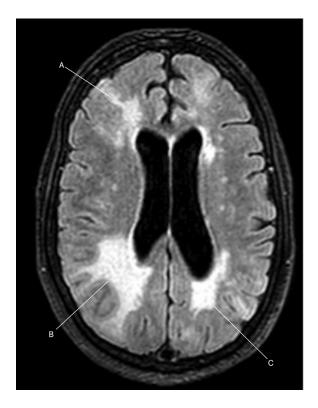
FLAIR demonstrating subcortical white matter hyperintensity to right frontal (A) and temporo-parietal (B) and left parietal regions (C), with vasogenic oedema and sulcal effacement.
